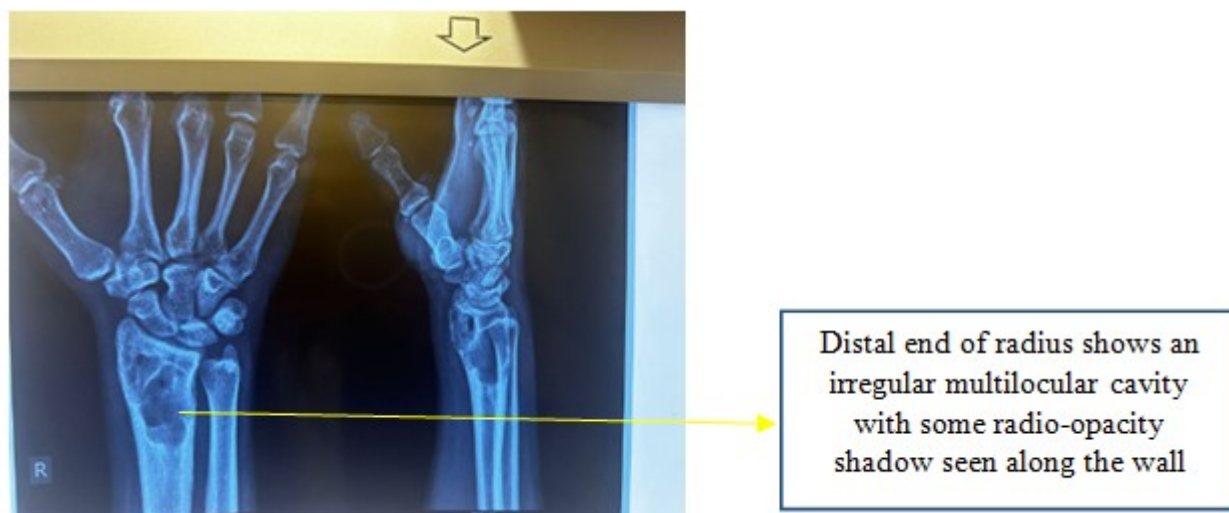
Pre-op Xray of Wrist Joint (Right side)
